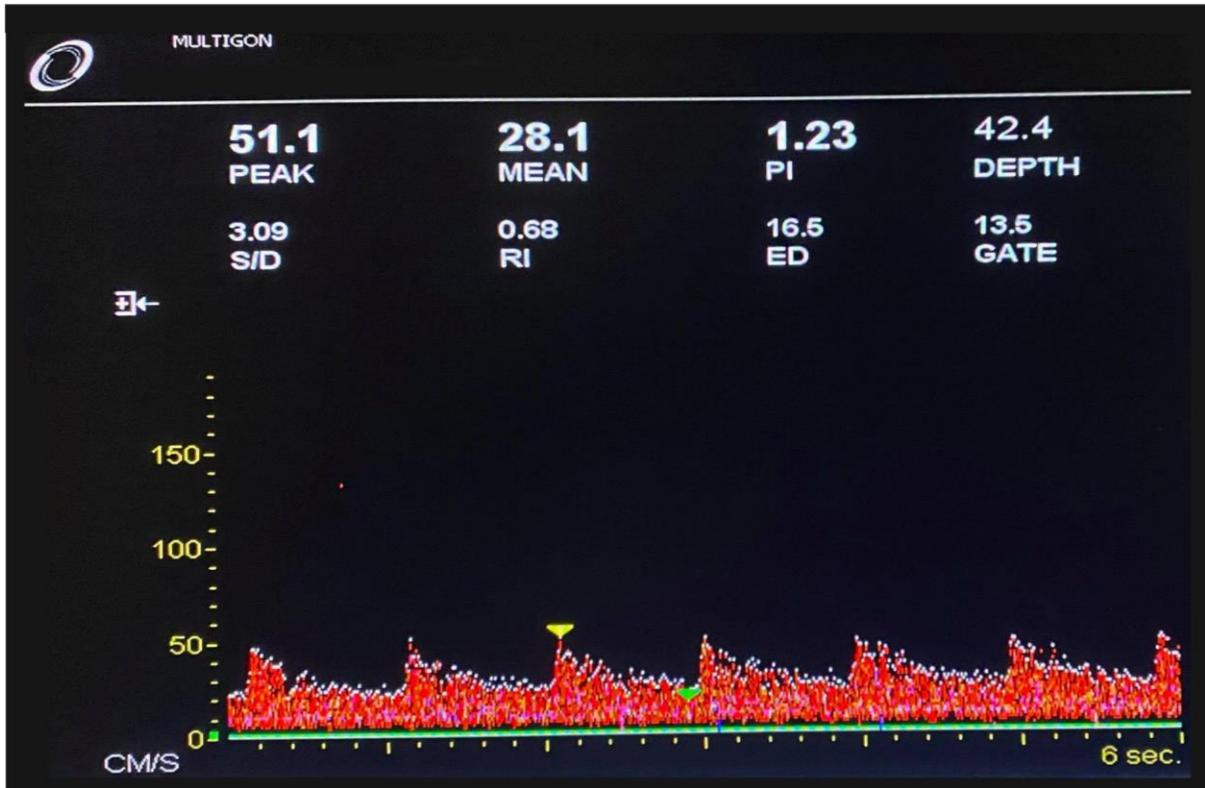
An image of the screen of the Multigon Doppler pulse wave tracing of the middle cerebral artery capturing cerebral blood flow velocity (CBF_v).
